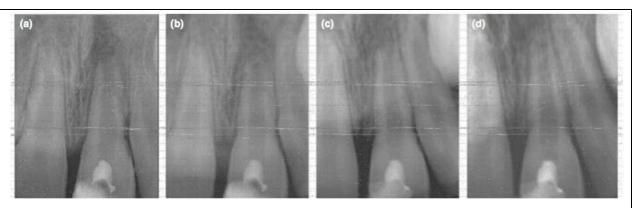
(from left to right): (a) Postoperative radiograph immediately after placement of PRF and definitive restoration; (b) 12-month recall; (c) 24-month recall; (d) 36-month recall.
